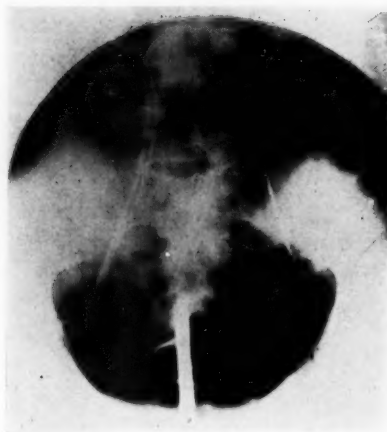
Lower urinary tract of Case IV. Upper point of crossing of ureters appears in this case to occur at much lower level than in other two cases. (X-ray work by Dr. A. L. Gray, Richmond, Va.)
